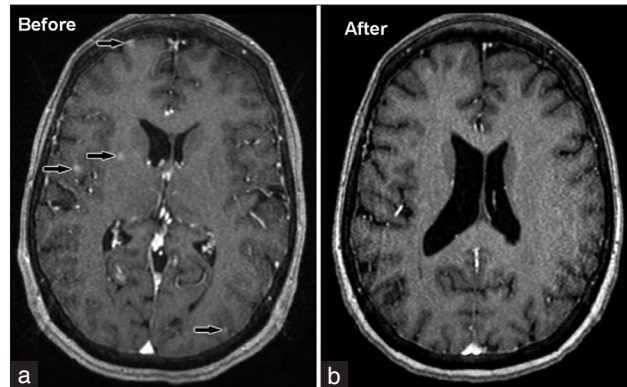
Magnetic Resonance Imaging of the brain (another view) before (a) and after erlotinib (b)
